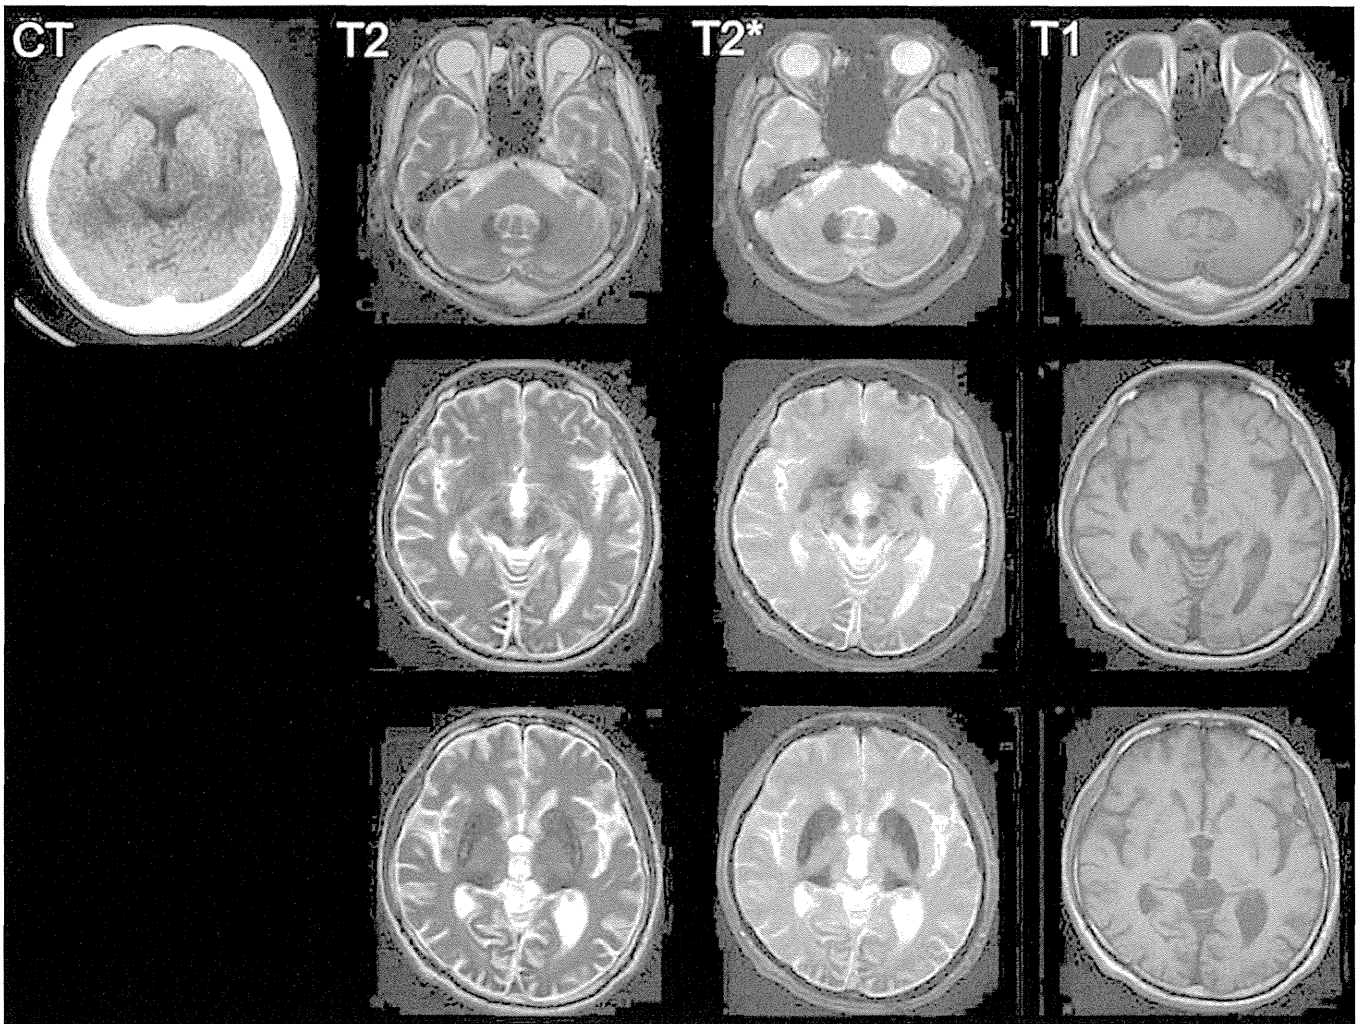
The brain CT and MRI findings of a patient with aceruloplasminemia. Brain CT showed abnormal high density areas in the basal ganglia. T1-, T2- and T2*-weighted axial images of the brain showed signal attenuation of the dentate nucleus of the cerebellum, globus pallidum, putamen, caudate nucleus and thalamus.
